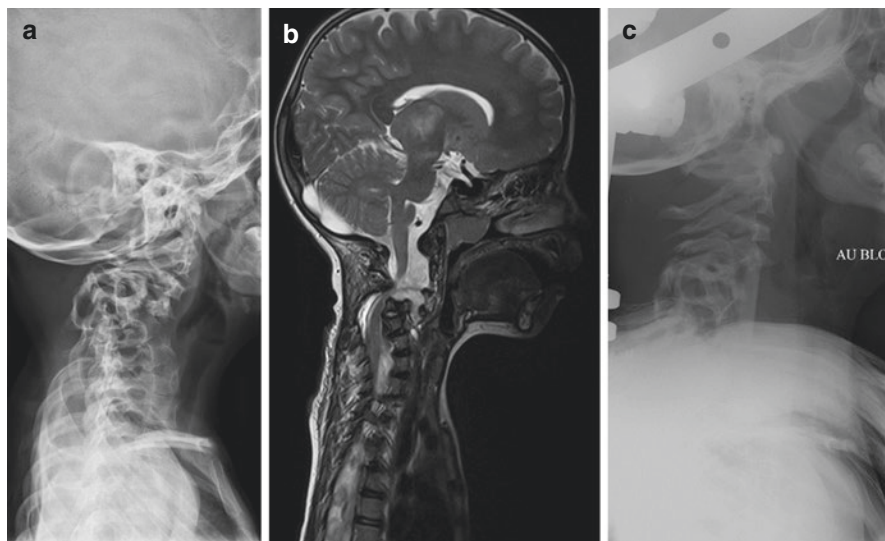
A patient with NF-1 and cervical kyphosis (a); MRI shows kinking of the cord and dural ectasia (b); anterior strut graft (tibia; c)
